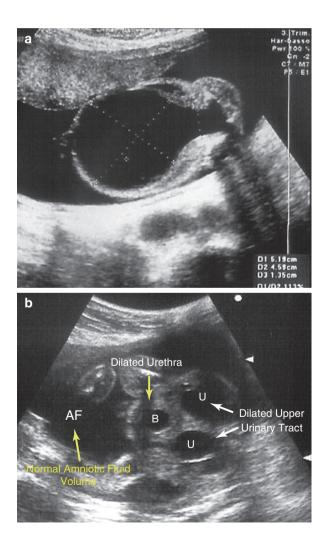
Ultrasound antenatal diagnosis. (a) Antenatal US of a male fetus at 20 weeks of gestational age, showing an enormously dilated bladder and dilated posterior urethra with normal amniotic fluid volume. (b) Antenatal US (21 weeks g.a.) shows a dilated upper urinary tract and dilated posterior urethra (arrow), under a not severely dilated bladder (B) but dilated ureters (U), with normal amniotic fluid volume (yellow arrow)
